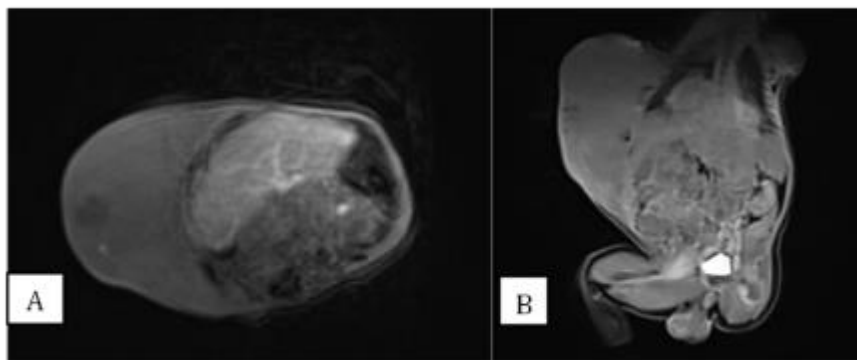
Contrast-enhanced T1-weighted MRI images in the axial and coronal planes demonstrate homogeneous enhancement of a subcutaneous mass involving the right chest wall and extending to the pelvic region. The imaging findings are suggestive of an infantile hemangioma.
